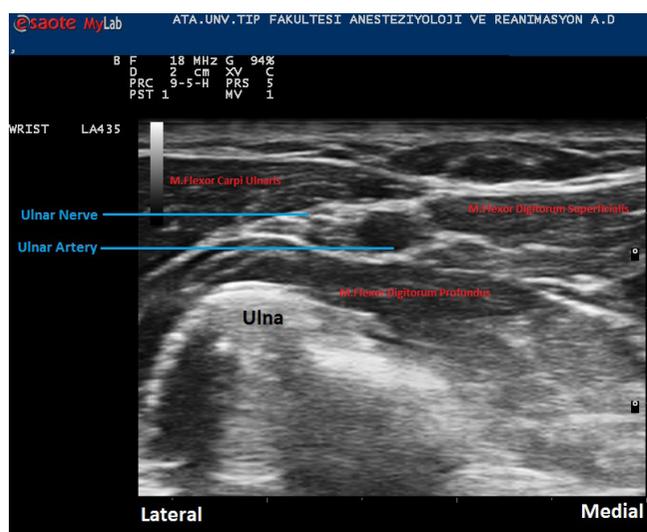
Ultrasound image of ulnar nerve
